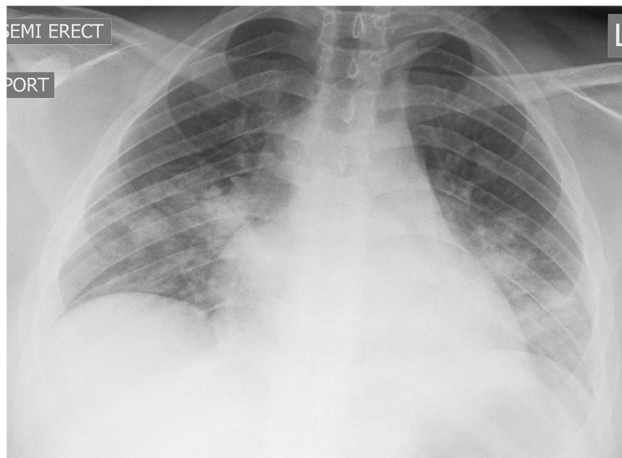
Ground-glass opacities on radiography in acute coronavirus disease 2019 (COVID-19) pneumonia. A 12-year-old obese boy presented with fever, cough and hypoxia. Anteroposterior chest radiograph demonstrates ill-defined ground-glass opacities in both the mid and lower lung fields, with superimposed patchy perihilar consolidation
